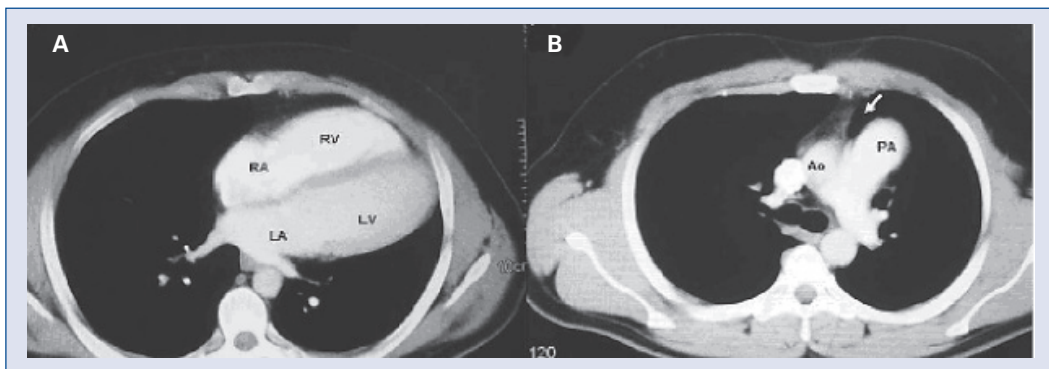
A. Transverse thorax computed tomography (CT) image showing dilatation of the right ventricle and levoposition; B. Transverse thorax CT image at the level of the aorto-pulmonary window showing interposition of lung tissue between the aorta and main pulmonary artery (arrow) which is pathognomonic for absence of pericardium in this region; LA — left atrium; LV — left ventricle; RA — right atrium; RV — right ventricle; Ao — aorta; PA — pulmonary artery.
